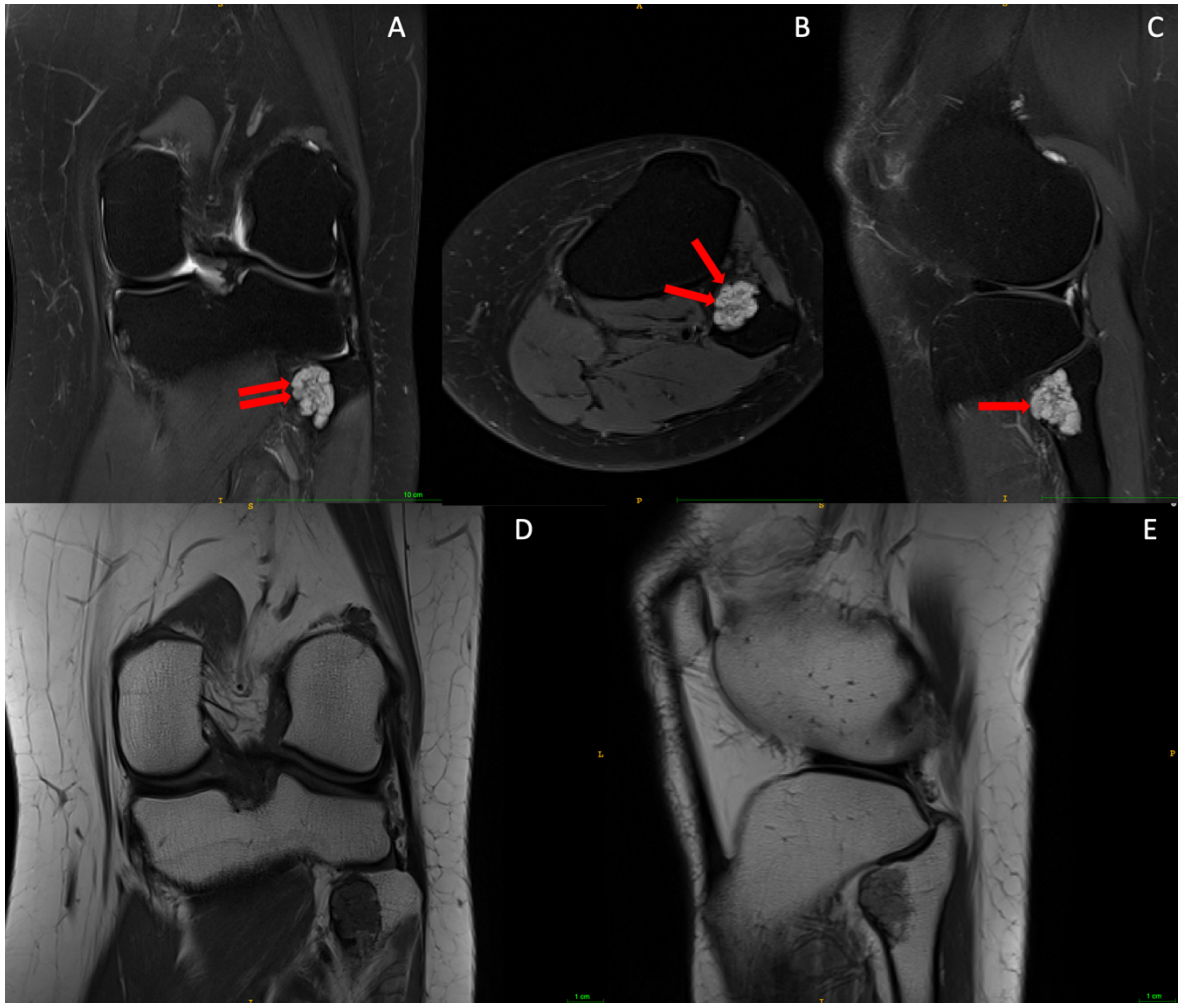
MRI of an ACT (deep endosteal scalloping [red arrows], no periosteal reaction, no perilesional edema, tumour size of 2.1 cm) of the left fibula (female, 48 years): (A) proton density, fat suppression, coronal, turbo spin echo; (B) proton density, fat suppression, transversal, turbo spin echo; (C) proton density, fat suppression, sagittal, turbo spin echo; (D) t1, coronal, turbo spin echo; (E) proton density, t2, sagittal.
